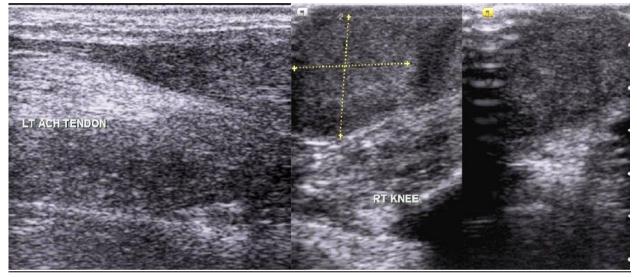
High resolution ultrasonography shows thickening of Achilles and patellar tendon with internal hypoechoic masses and loss of normal architecture.
